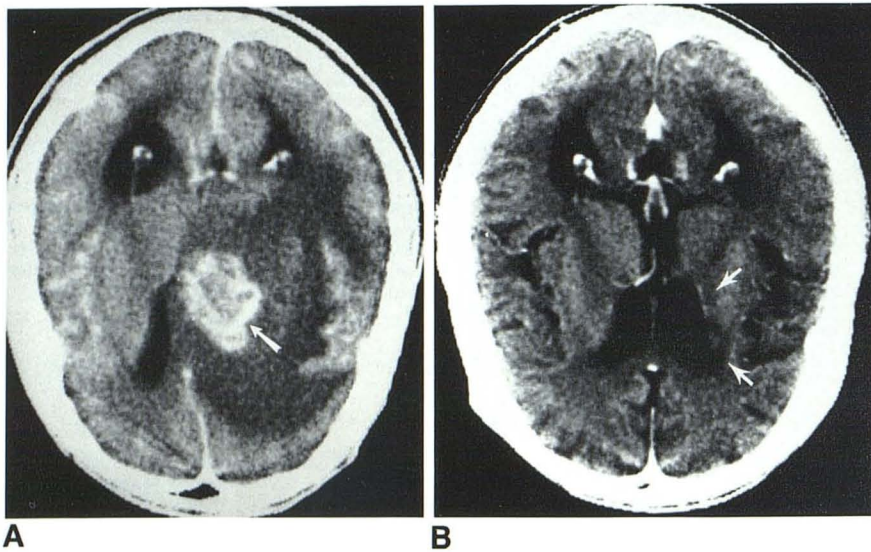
A, Initial high-resolution contrast-enhanced CT scan. Densely enhancing basal ganglionic mass (arrow) with edema and partial outlet obstructive hydrocephalus. B, 9 months later after therapy for biopsy-proven *Toxoplasma* encephalitis. Only residual low densities (arrows) with ex vacuo dilatation of adjacent frontal horn and diffuse cortical atrophy. (A reprinted from [7].)
